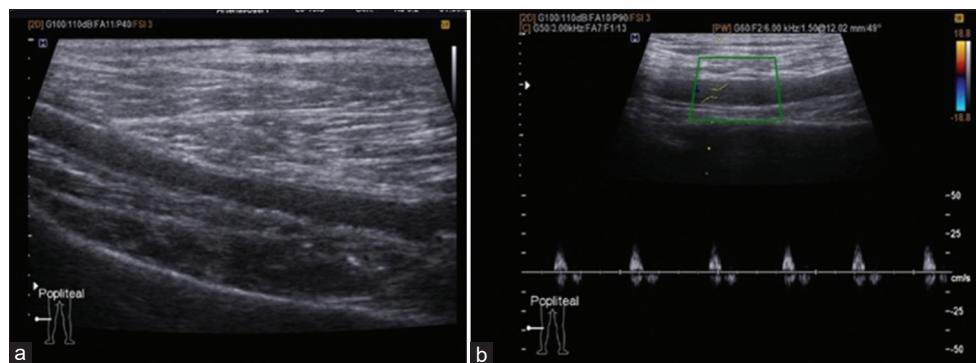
(a and b) Above-mentioned gray scale and pulse Doppler modes reveal atherosclerotic wall thickening and calcification in the popliteal artery with biphasic waveform patterns on pulse Doppler analysis
